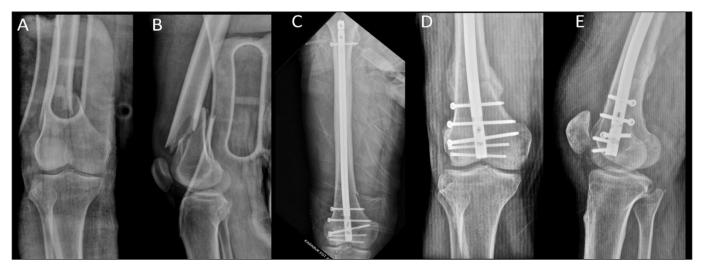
Anteroposterior (A) and lateral (B) radiographs of a 52-year-old male patient with a distal femur fracture treated with retrograde intramedullary nailing with a tibial nail (C). Anteroposterior (D) and lateral (E) radiographs demonstrating fracture healing
